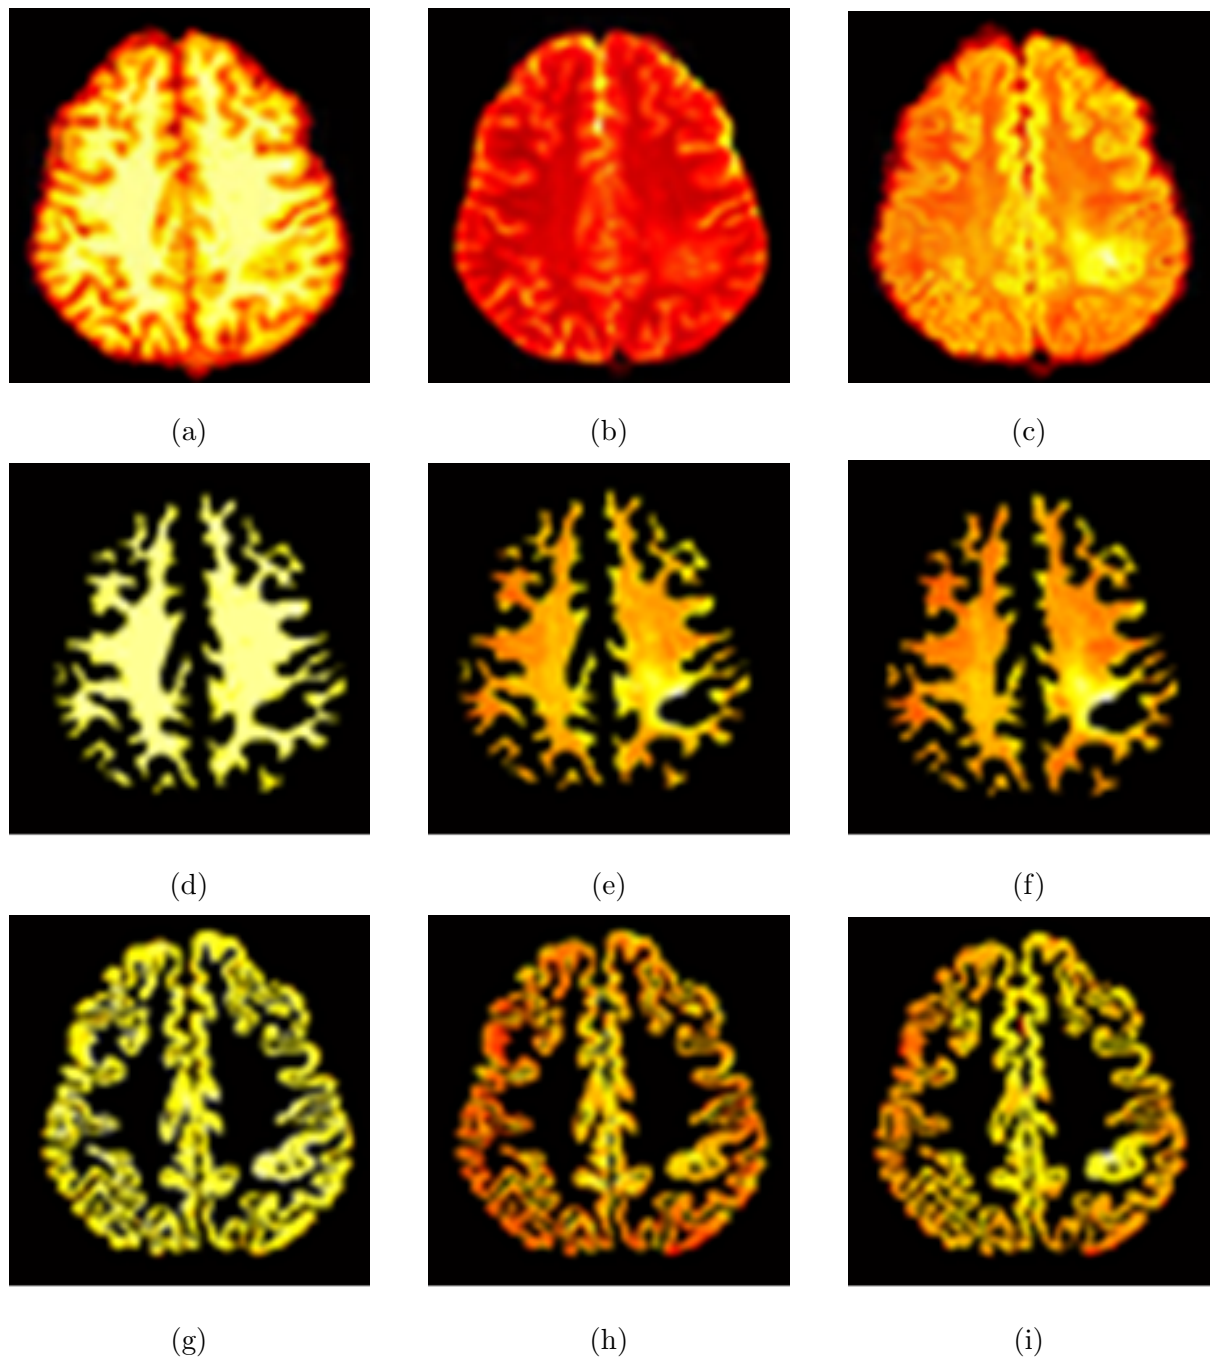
Segmenting and normalizing gray and white matter for abnormal signal detection. (a) Original T1-weighted, (b) Original T2-weighted, (c) Original FLAIR, (d) T1-weighted white matter normalized, (e) T2-weighted white matter normalized, (f) FLAIR white matter normalized, (g) T1-weighted gray matter normalized, (h) T2-weighted gray matter normalized, (i) FLAIR gray matter normalized
